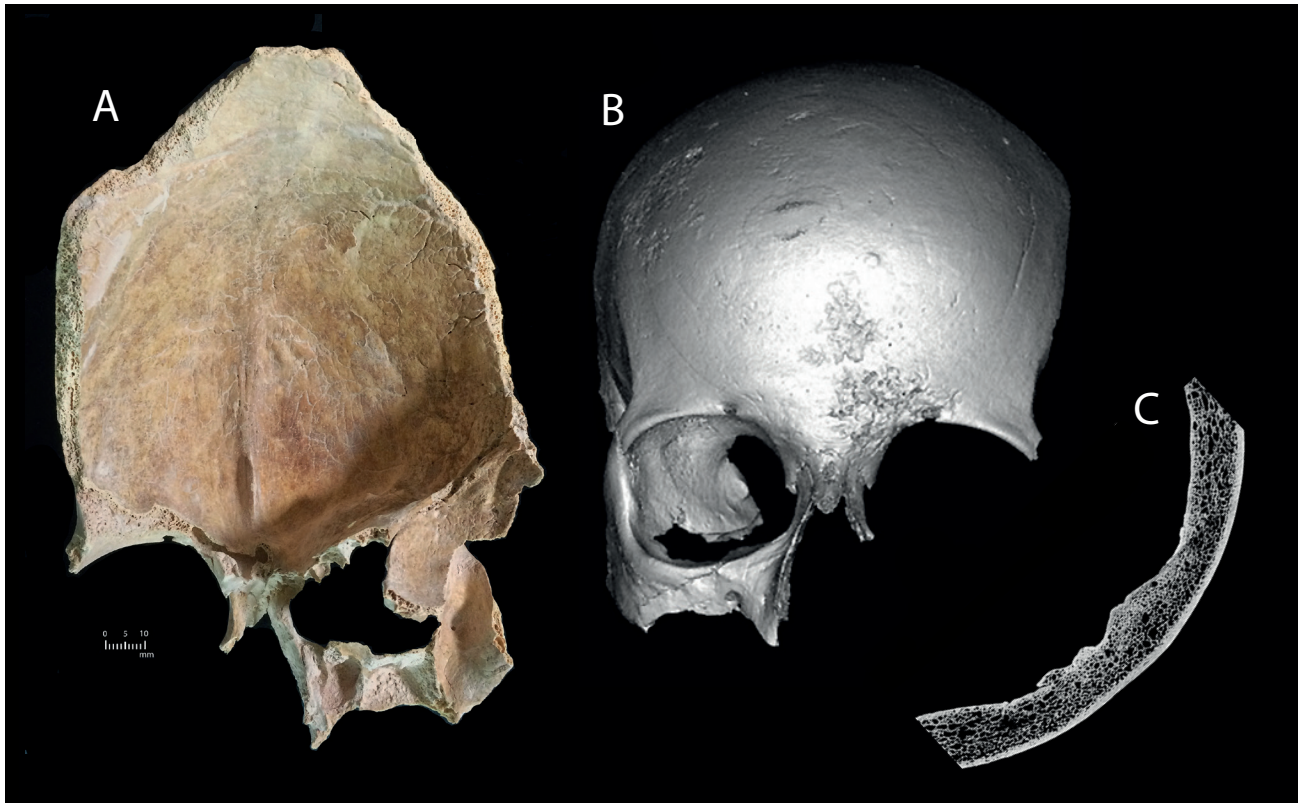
A selection of photographic and radiological images pertaining to a fragmentary adult possible female cranium (FB0024), with extant portions of adult frontal bone, partial left and right nasal bones, partial frontal processes of left and right maxillae, partial right zygoma, and partial right greater wing of sphenoid from Context (1268) of the Circle sample, detailing a proliferative endocranial lesion within the frontal fossa, including: a) endocranial view; b) 3D rendered anterior view; c) cross-section from CT data. Scale bar: 1 cm (photograph only). (Photo Ronika K. Power; radiological images captured by L. Buck, Cambridge Biotomography Centre; processed by J. Magnussen & M. Pardey, Macquarie Medical Imaging).
